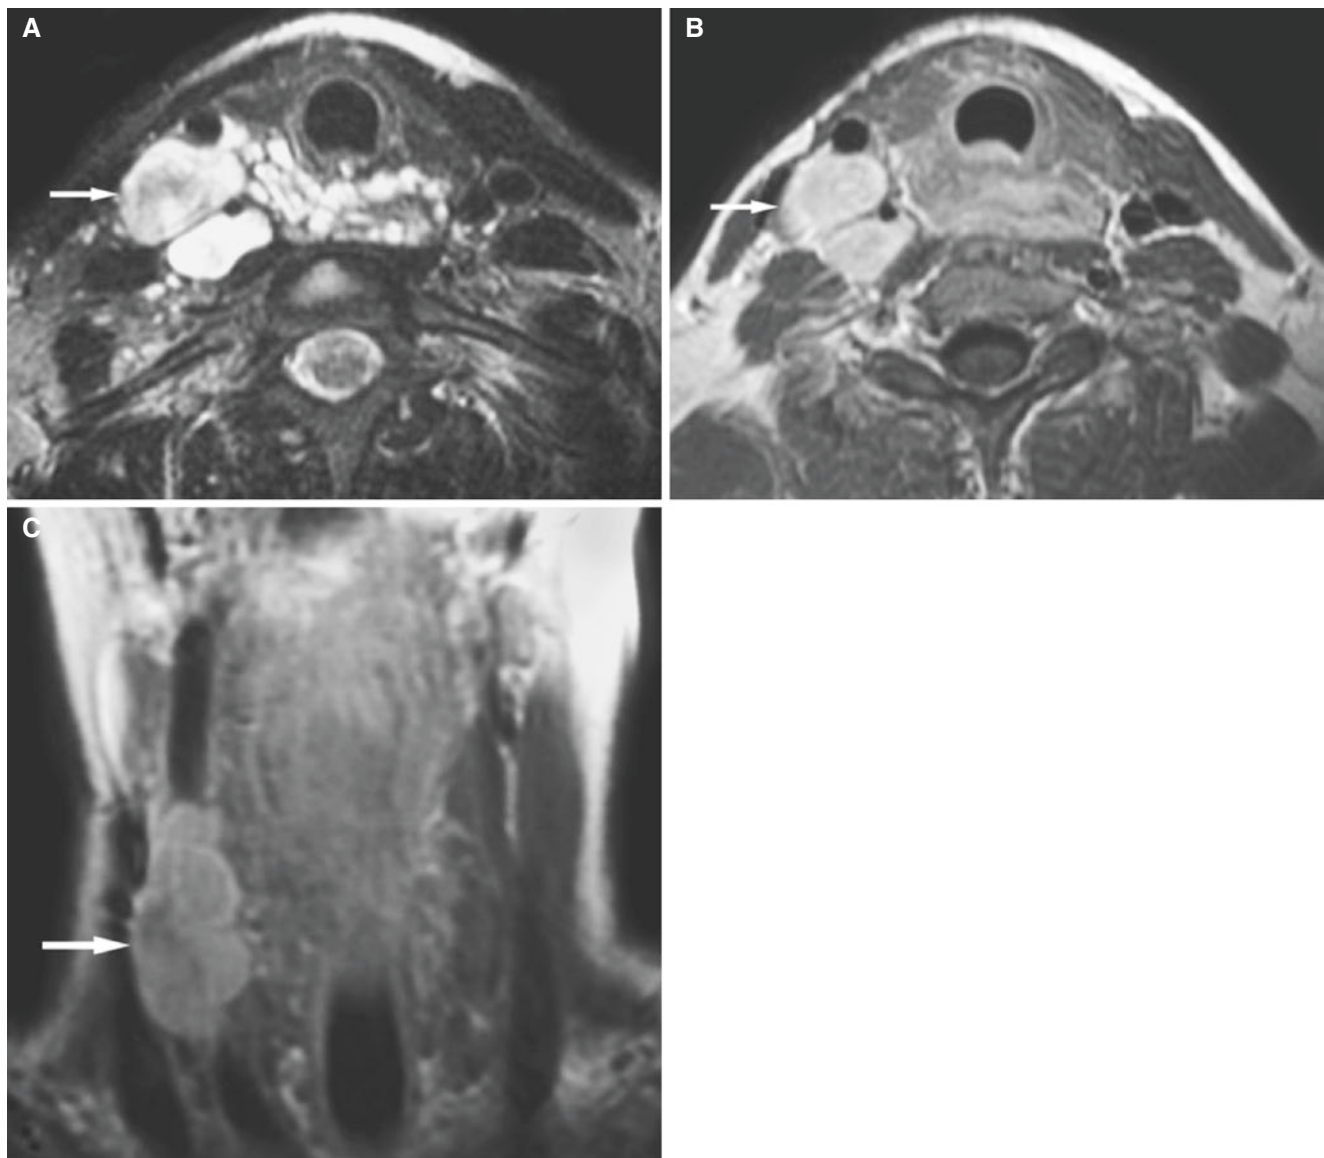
Plexiform neurofibromatosis; 9-year-old female presents with a painless swelling of right lower neck. (A) Axial T2-weighted fat-suppressed MRI shows multilobulated complex mass in the right lower neck extending across midline (*arrow*), separating common
